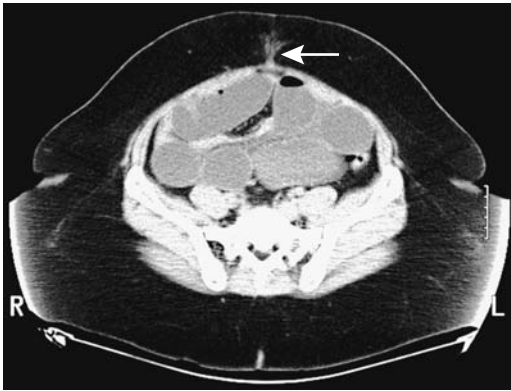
An incisional hernia causing small bowel obstruction after laparoscopic surgery. CT identifies both the hernia (arrow) and marked proximal small bowel dilation. (Courtesy of Patrick Fultz, M.D., University of Rochester.)
